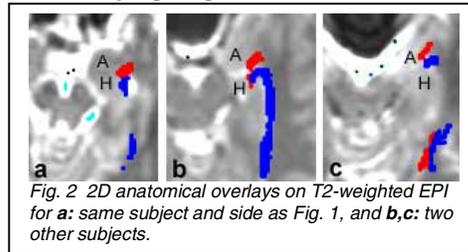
2D anatomical overlays on T2-weighted EPI for a: same subject and side as Fig. 1, and b,c: two other subjects.
